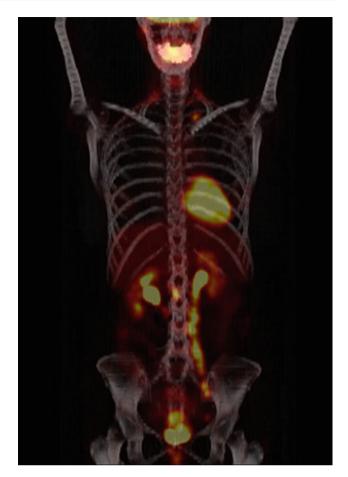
PET-CT and Staging of Cervical Cancer: A 43 year old woman with invasive squamous cell carcinoma of the cervix underwent PET-CT revealing retroperitoneal and supraclavicular adenopathy, consistent with Stage IV disease
